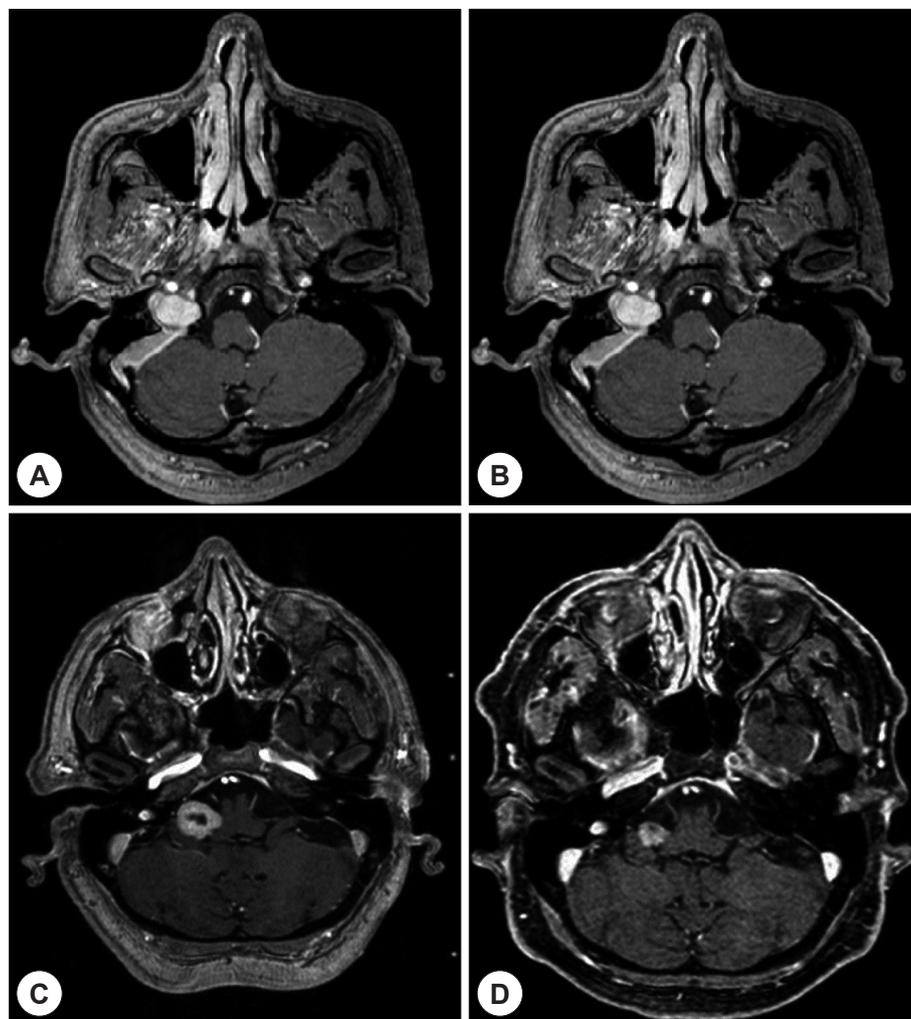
The scans show marked shrinkage of the jugular foramen schwannoma. Axial T1-weighted contrast-enhanced magnetic resonance images obtained before gamma knife radiosurgery (A and C), and 24 (B) and 41 months (D) after gamma knife radiosurgery (A and B: Case No. 4, C and D: Case No. 5).
